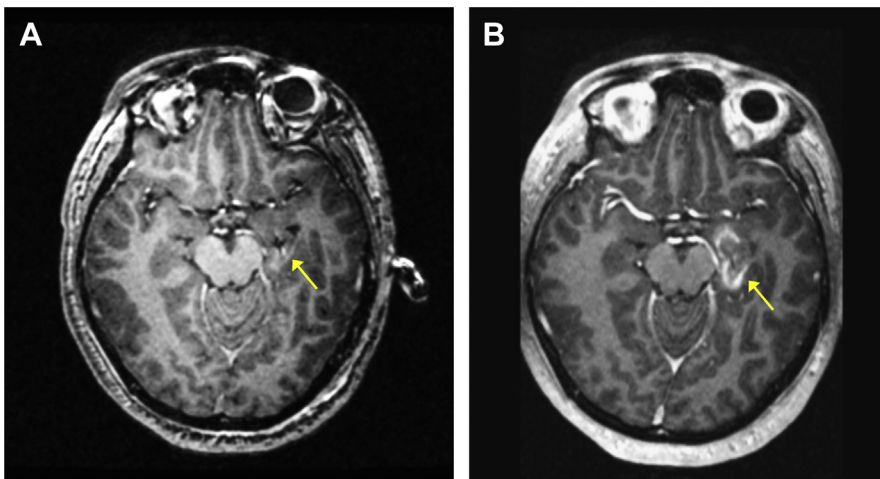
LITT provides focal ablative therapy without damaging surrounding tissue. (A) Intraoperative MRI confirms placement of the water-cooled fiber optic applicator in the hippocampus (*arrow*), and laser energy is used to heat the tissue to ablative levels. (B) Gadolinium contrast forms a ring around the damaged tissue following ablation.
